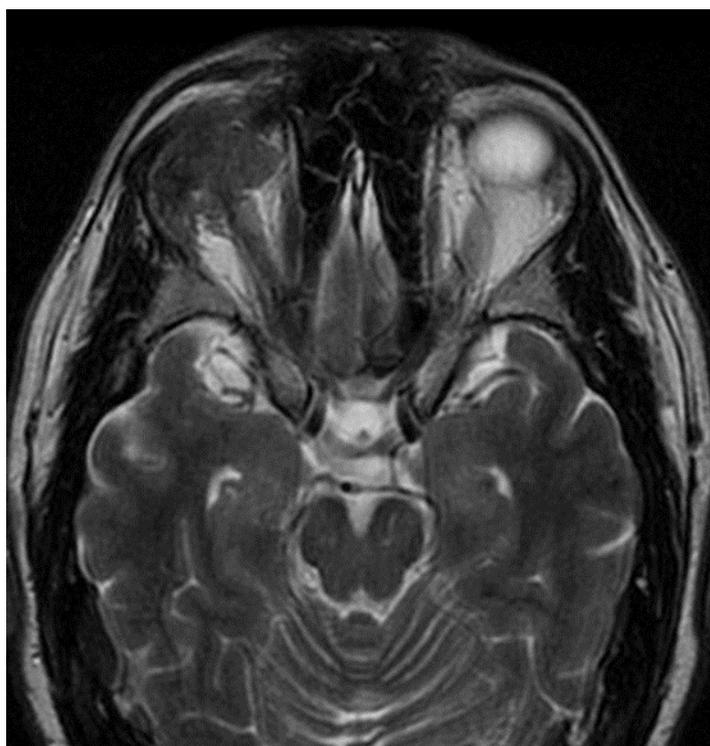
Magnetic resonance imaging fragment of Patient V., a 65-years-old man
